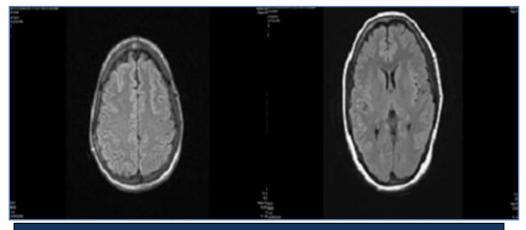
Cranial MRI of a patient with eclampsia at 2 months after initial presentation showing complete resolution of cerebral changes
